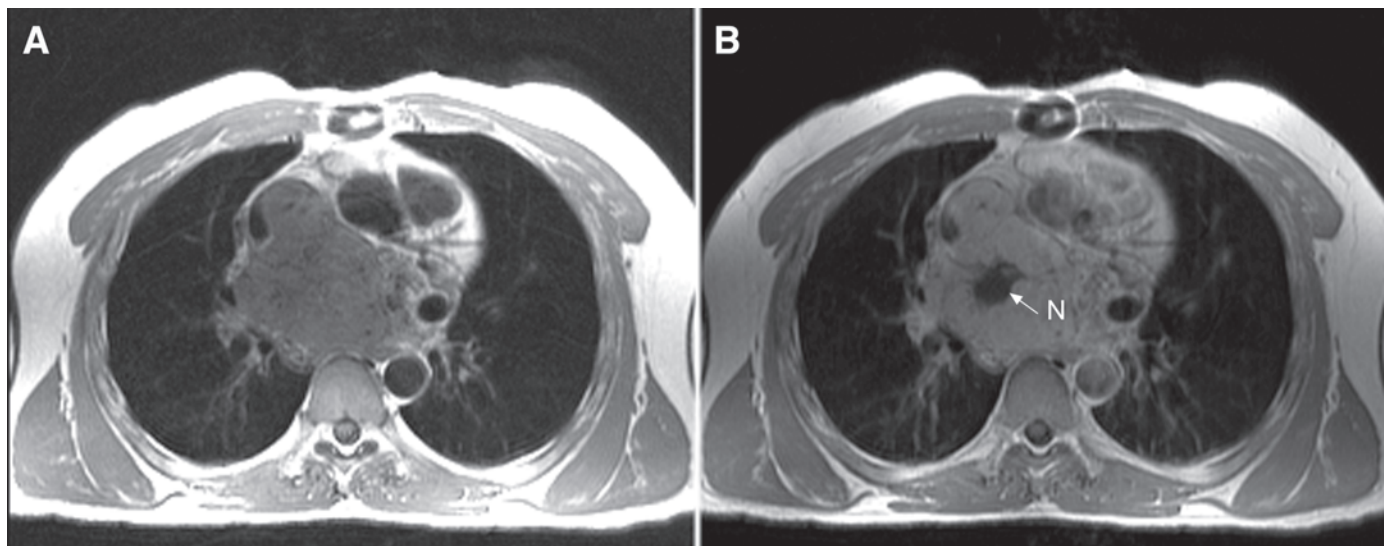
Corresponding T1 weighted axial magnetic resonance imaging sections before (A) and after (B) contrast administration show massive enhancement of most tumor parts except a central necrosis (N).
